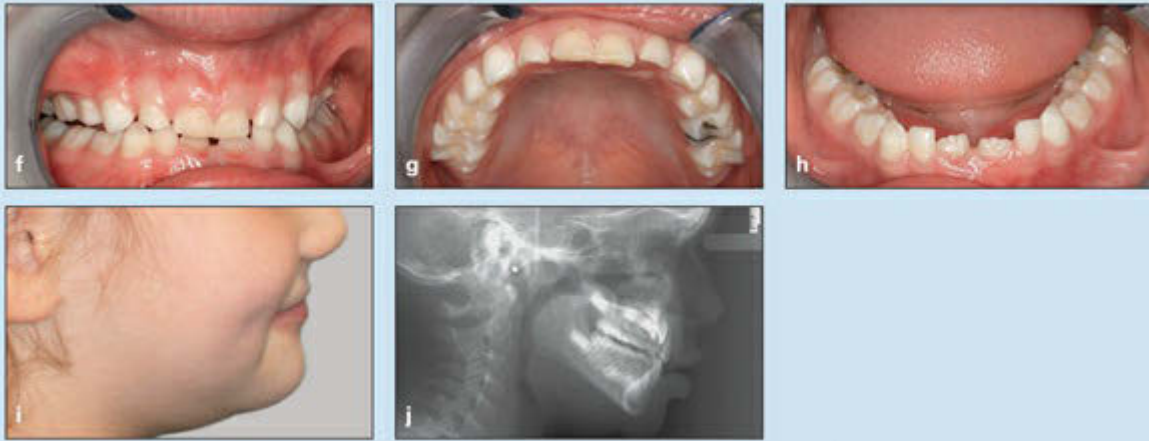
(cont) (f to h) Posttreatment occlusion. (i) Posttreatment soft tissue profile. (j) Posttreatment cephalometric radiograph.
